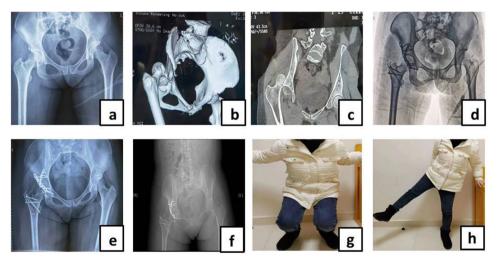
A 28-years-old female, who sustained a road traffic accident and presented with right Pipkin IV femoral head fracture: (a) preoperative X-ray image of the; (b) 3D CT showed fracture of the femoral head with fracture of the posterior wall of the acetabulum; (c) 2D CT scan coronal section showing posterior dislocation of the fractured femoral head; (d), (e) and (f) reveal the postoperative radiographic images at respectively one day, three months and one year. (d) and (h) demonstrate a good hip function at one year follow-up
